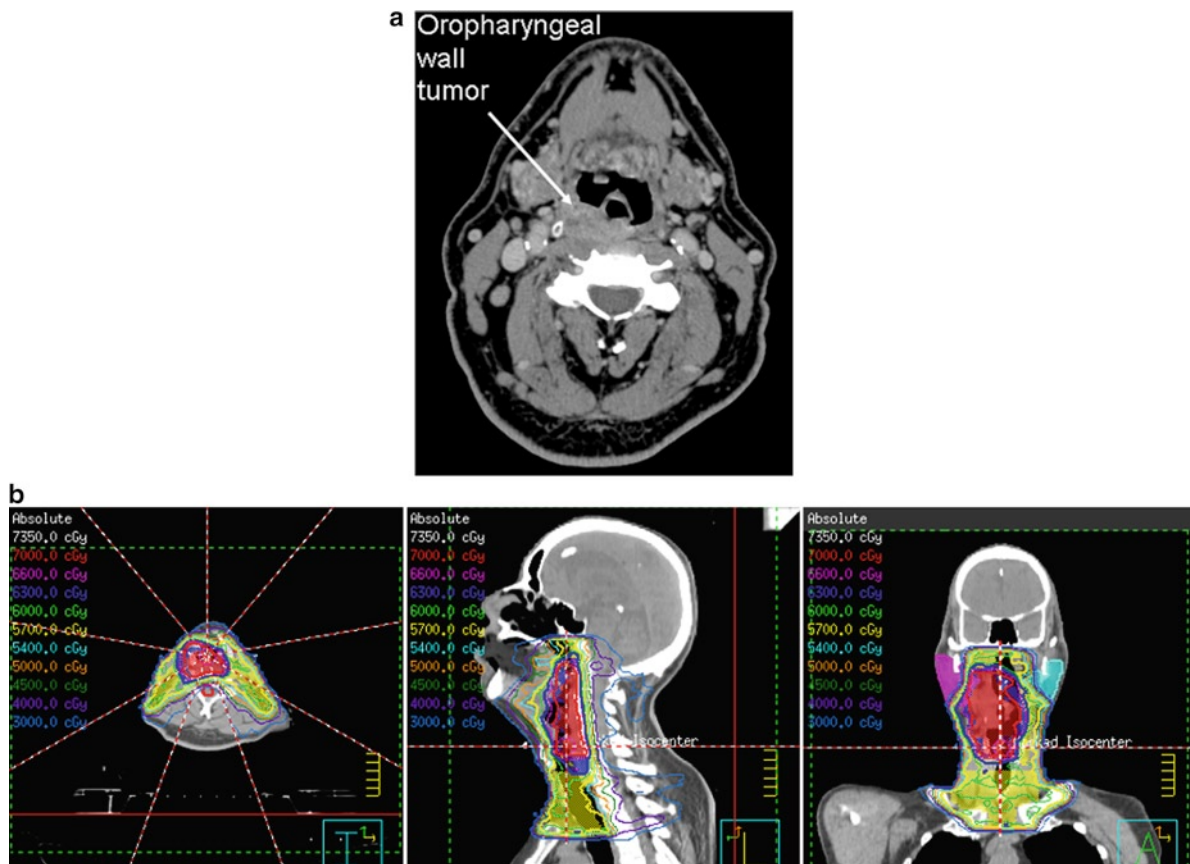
Oropharyngeal wall tumor (a) Initial contrast-enhanced CT appearance of a T3 N1 squamous cell carcinoma of the right oropharyngeal wall (b) IMRT treatment plan for definitive chemoradiation of this lesion to a dose of 70 Gy in 33 fractions
